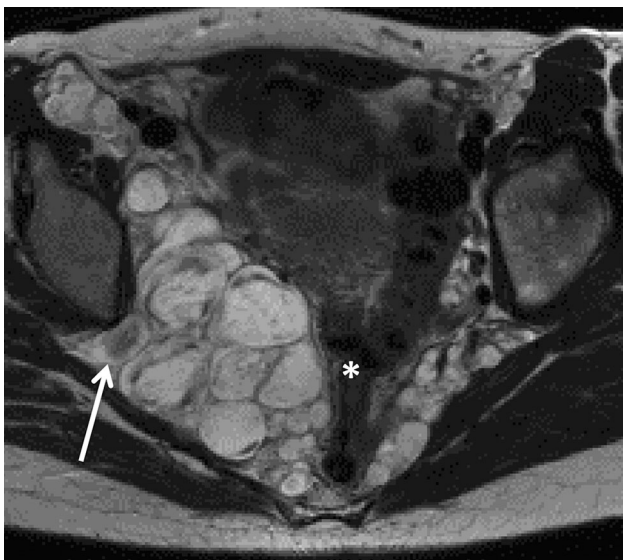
Plexiform neurofibroma. Axial T2-weighted image demonstrates large plexiform neurofibromas in the pelvis with mass effect on the rectum (asterisk). Note the high T2 signal intensity with the target sign (arrow) due to a central low signal intensity fibrous core.
